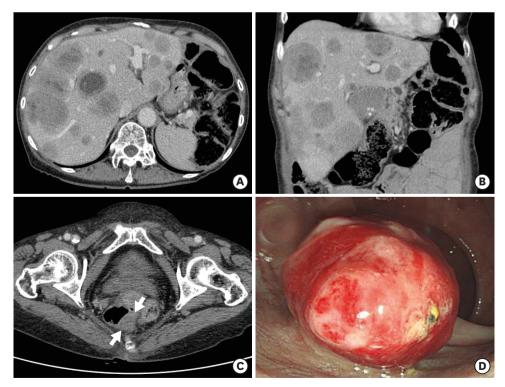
Image and gross findings of neuroendocrine tumors of the liver and rectum. (A) Computed tomography image of liver lesions in the axial view. (B) Computed tomography image of liver lesions in the coronal view. (C) Computed tomography image of the rectal lesion in the axial view (arrows). (D) Gross finding of the rectal mass by colon fibroscopy.
